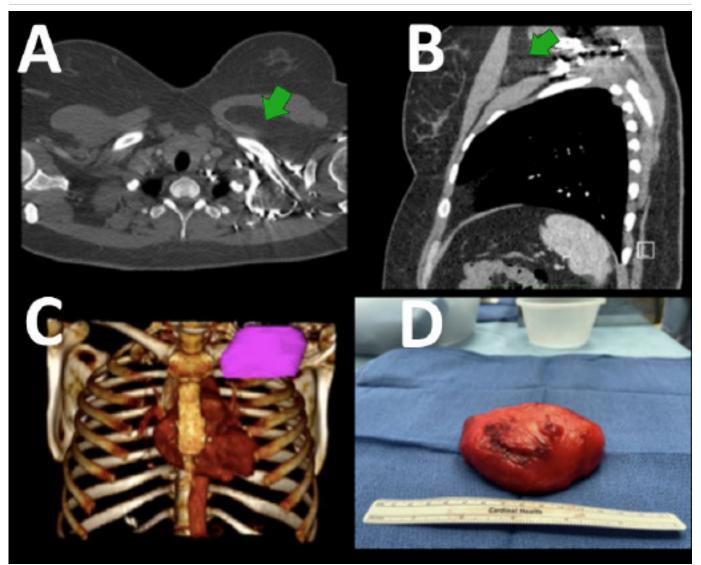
A) Axial CT Scan (green arrow denotes mass), B) Coronal CT Scan (green arrow denotes mass), C) 3D Reconstruction (mass in red), and D) Resected Lipoma. Published with Permission
